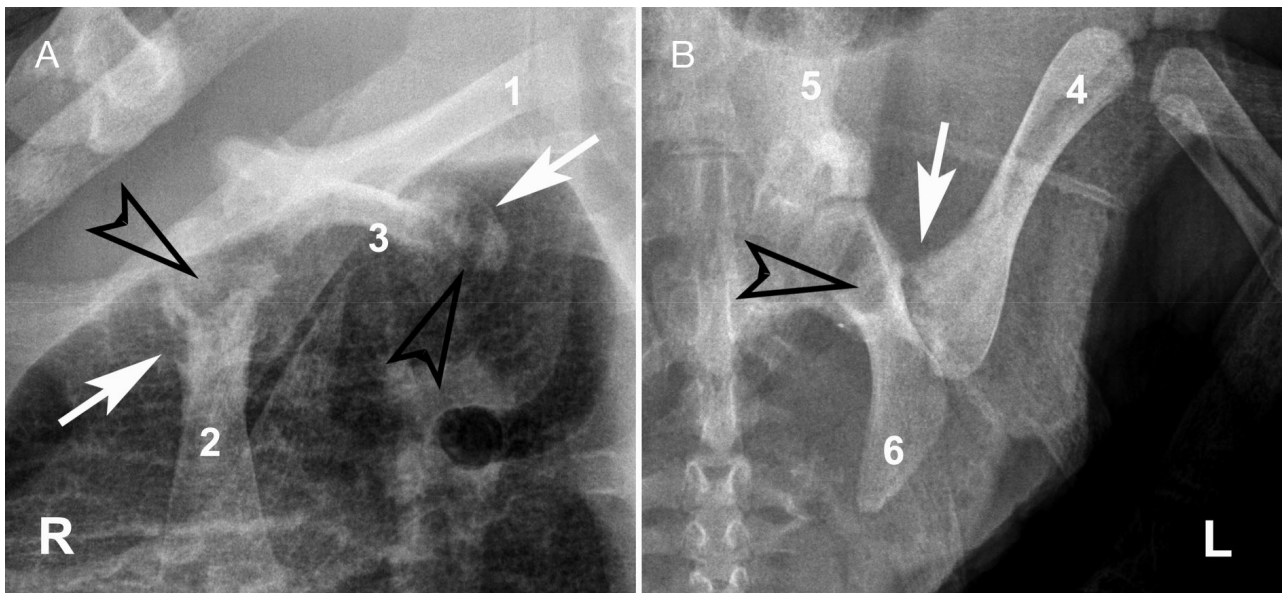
Final control radiographs of the (A) right pectoral and (B) left pelvic girdle in dorso-ventral view (cf. Fig. 1). In (A) there are still visible bone lyses on the acromion process and at the level of the coracoid (empty arrowheads) but, at the same time, areas of sclerotic and periosteal proliferation surround the lesions (white arrows). In (B) the left femoral head is lytic and partially superimposed to the acetabulum (empty arrowhead); a slight periosteal proliferation and bone sclerosis are visible on the neck and proximal diaphysis of the femur (white arrow). R: right body side; L: left body side; 1: scapula; 2: coracoid; 3: acromion process; 4: femur; 5: ileum; 6: ischium
